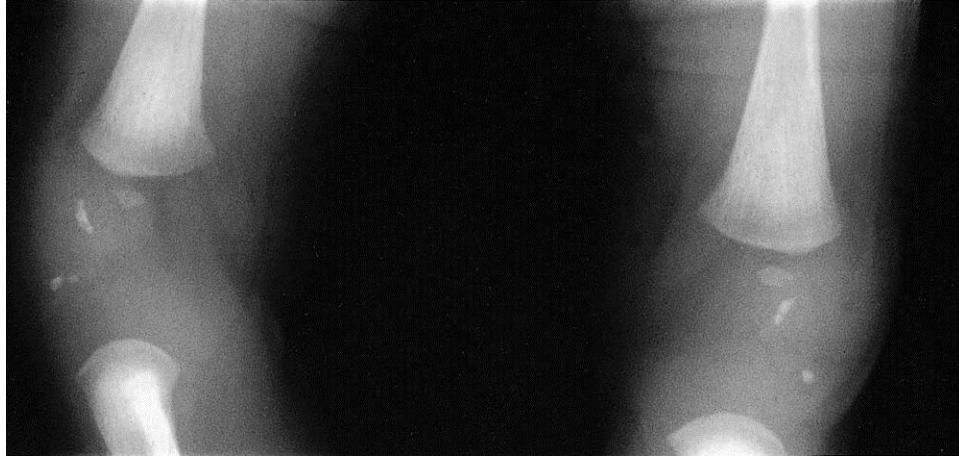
Radiograph of the knee of a newborn infant with Zellweger syndrome showing abnormal punctate calcification of the distal femoral epiphyses.
